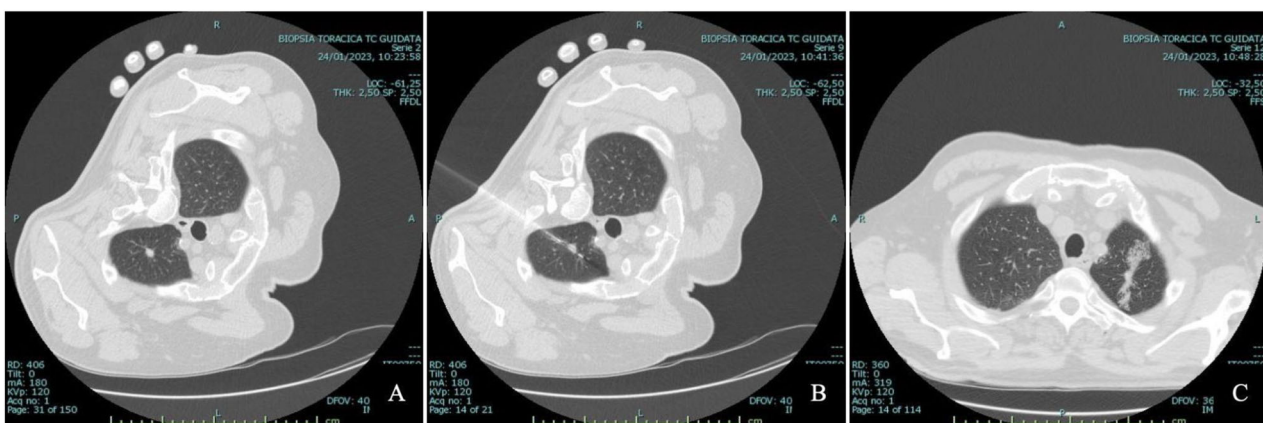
Biopsy in ipsilateral decubitus position. A Unenhanced axial CT scan shows a about 10 mm solid lesion in the left upper lobe of a 71-year-old patient. B Unenhanced axial CT scan depicts an 18G biopsy needle with its style inside the lesion. C Unenhanced axial CT scan obtained after the patient’s rapid roll-over shows limited hemorrhage on the lesion’s front side and blood track sealing on the lesion’s posterior side
